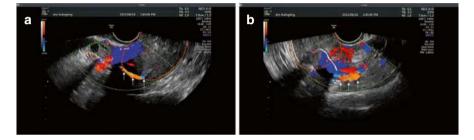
(a) Contrast agent flow in the right fallopian tube shown in color Doppler mode. The uterus is outlined in orange, the right ovary is outlined in green, and arrows indicate the tubal trajectory. (b) Contrast agent flow in the left fallopian tube shown in color Doppler mode. The uterus is outlined in orange, and arrows indicate the tubal trajectory
